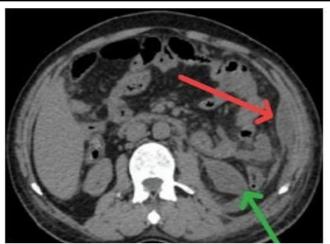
Computed tomography image of abdomen showing multiple hypodense collection in the abdomen
